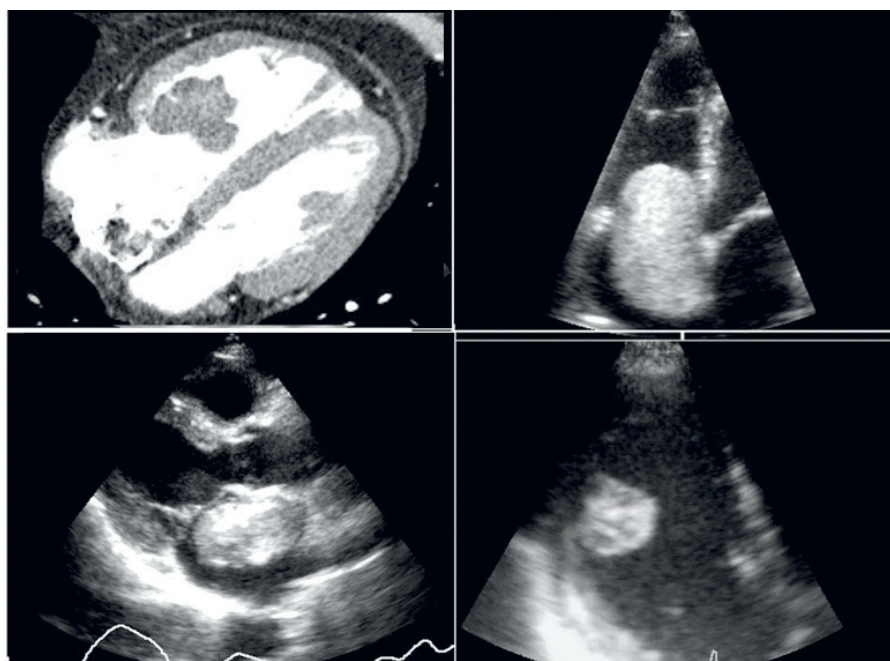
Changes in the topography and morphology of cardiac myxomas. A. A tumor with ragged “cluster-of-grapes” appearance in the inflow portion of the right ventricle, partially connected to the subvalvular apparatus of the tricuspid valve (contrast-enhanced CT). B. A large cylindrical pedunculated tumor narrowing the orifice of the tricuspid valve. C. Left atrial tumor limiting mitral leaflet mobility. D. Pedunculated lobular tumor in the left atrial appendage
